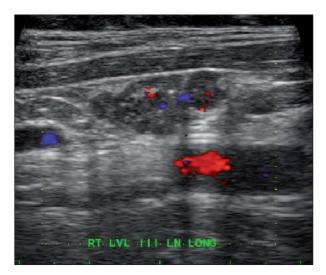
Grayscale ultrasound with color Doppler showing Level III LN, with irregular border, internal punctate calcifications, disorganized blood flow and absent hilum. Pathology showed NN-GI (Patient 1)
